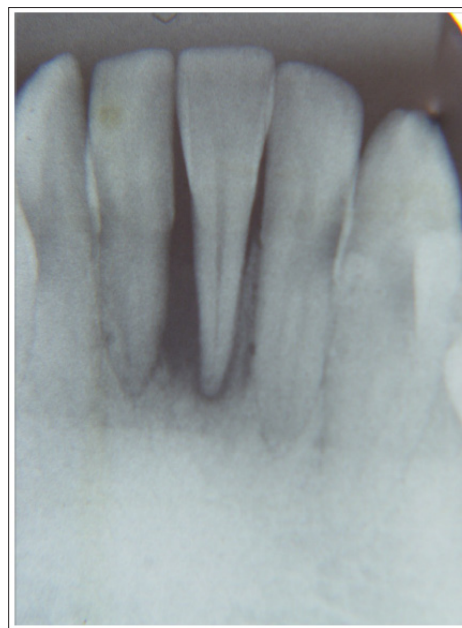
Periapical X-Ray Indicated Severe Vertical Bone Resorption on Teeth 41 and 31
